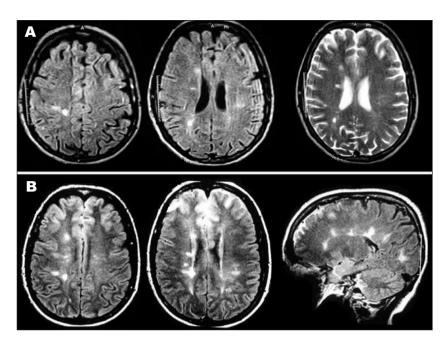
(A) First relapse (2003): multiple areas of high signal on axial FLAIR and T2-weighted images in the periventricular and subcortical white matter of the brain hemispheres. (B) Second relapse (2006): high signal on axial and sagittal FLAIR images in some periventricular and subcortical areas of white matter of the brain hemispheres.
